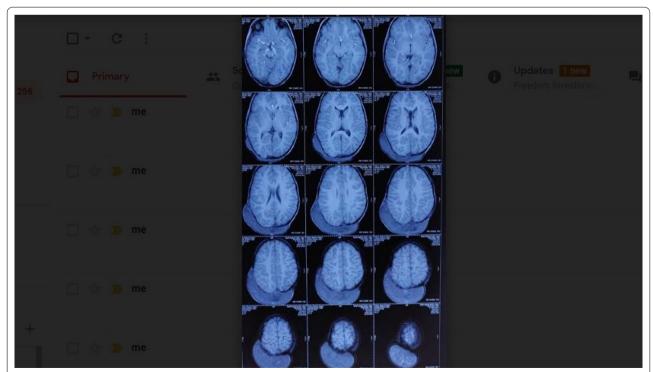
T1-weighted axial non-contrast images show a large heterogeneously hyperintense swelling over bilateral parieto-occipital region of the scalp suggesting haemangiolymphoma
